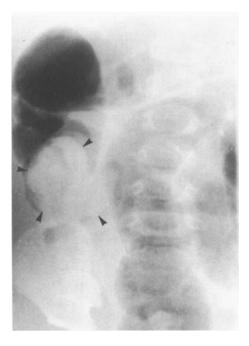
Radiograph following an air contrast enema, outlining an ileocolic intussusception during reduction. The intussusceptum (arrowed) has been reduced to the caecum
